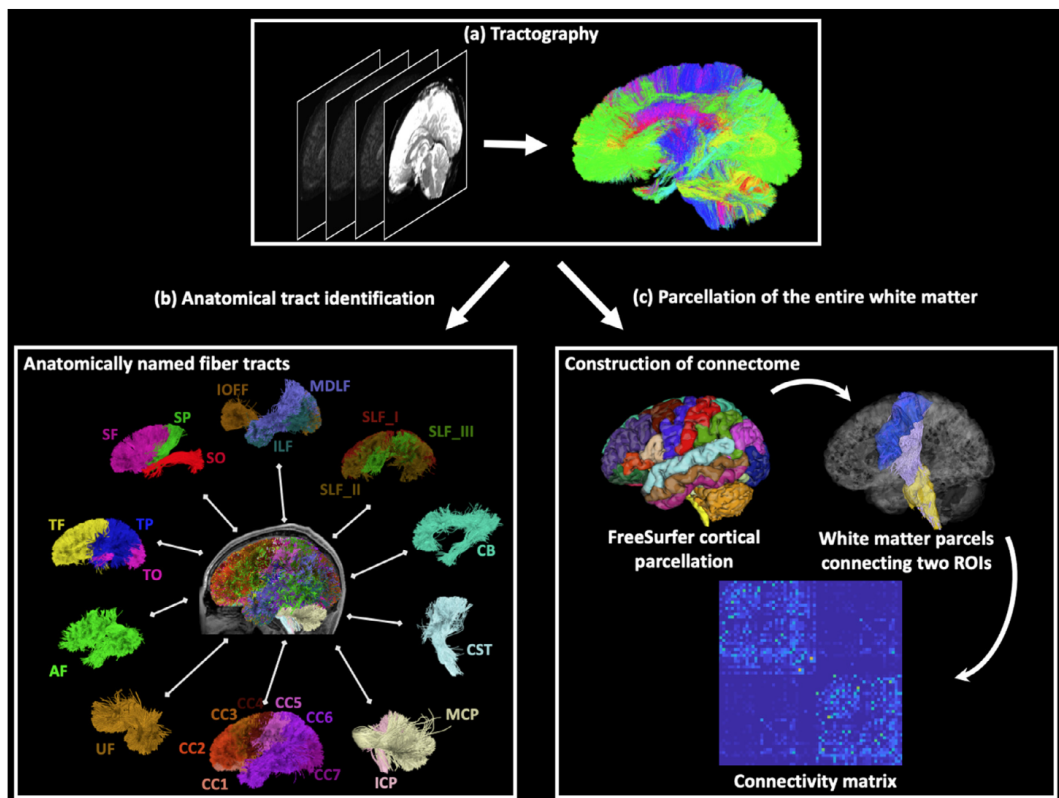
Tractography segmentation: (a) whole-brain tractogram computed by performing tractography in DWI data; (b) example anatomical tracts extracted from the tractogram; (c) example structural connectivity matrix constructed by performing tractography segmentation between all pairs of FreeSurfer cortical regions. Source:[43]
